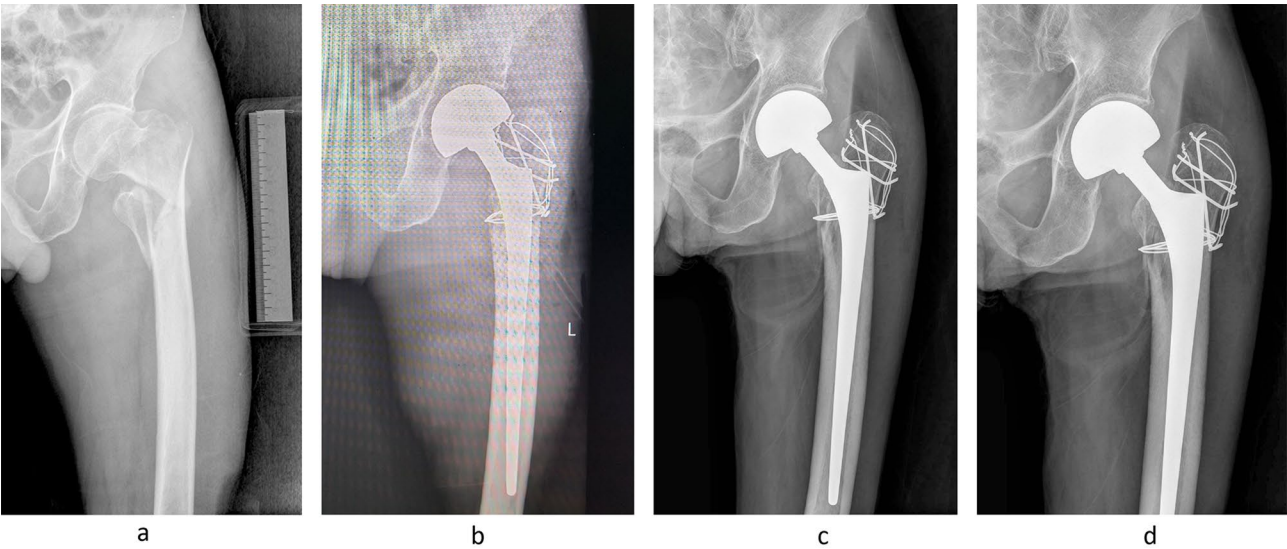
An 80-year-old man with right hip pain following a fall. (a) Radiographs showing a comminuted fracture between the left femoral intertrochanteric region. (b) He underwent long-stemmed bipolar cemented hemiarthroplasty (LCHA). (c) First-month postoperative X-ray. (d) Follow-up X-rays taken in the first year after surgery
